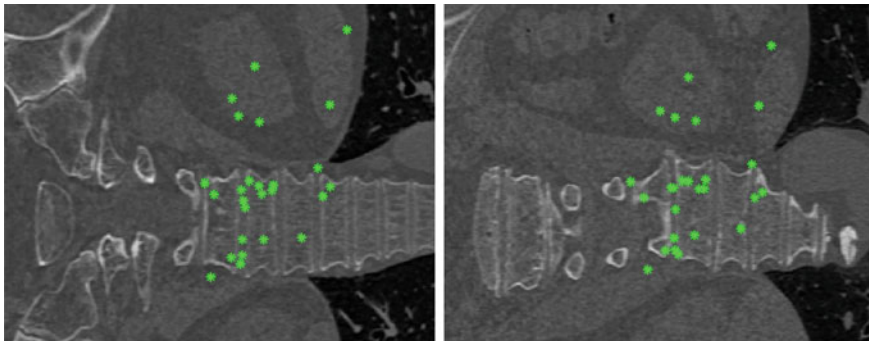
Two CT slices of a target image (*left*) and an atlas image (*right*) with corresponding features after RANSAC for lumbar vertebra 1
